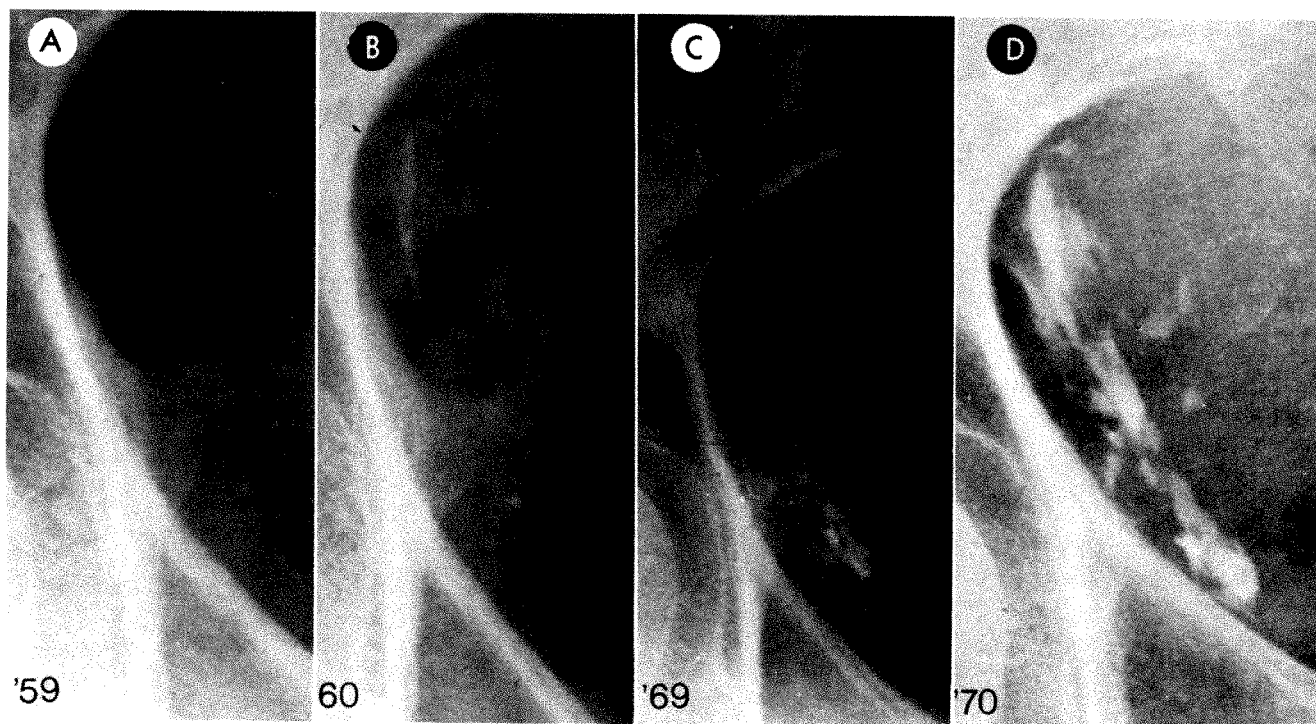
Serial radiographs showing progression of calcification over 11-year period.
